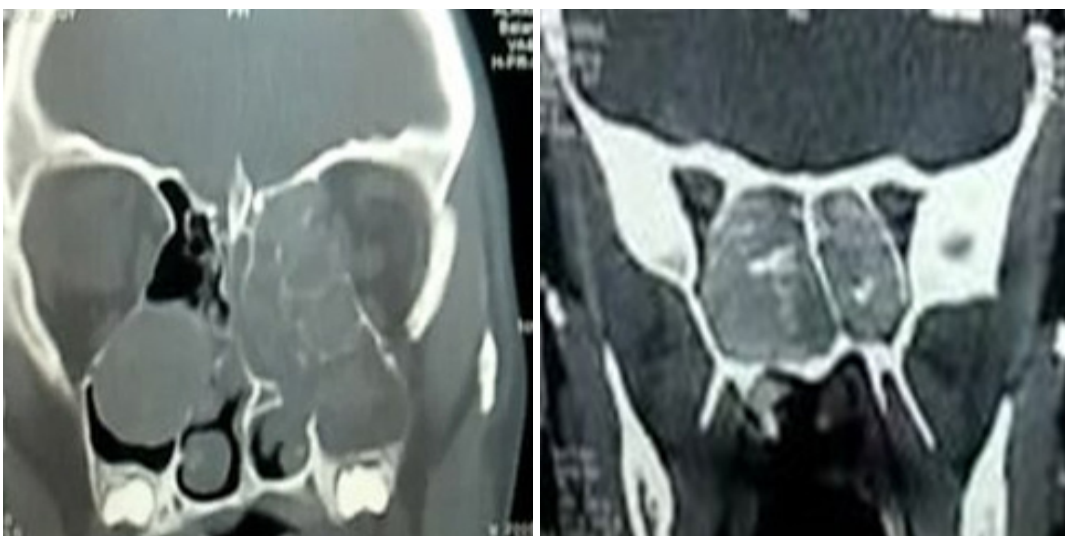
Preoperative coronal CT showing bilateral AFS
